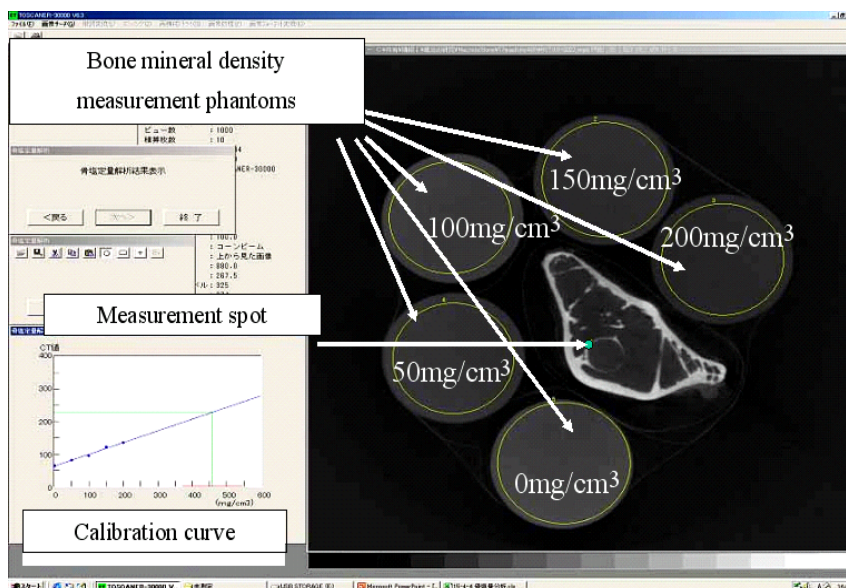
Measurement method of bone mineral density using Micro CT (HA content of standards: 0, 50, 100, 150, 200 mg/cm<sup>3</sup>).
